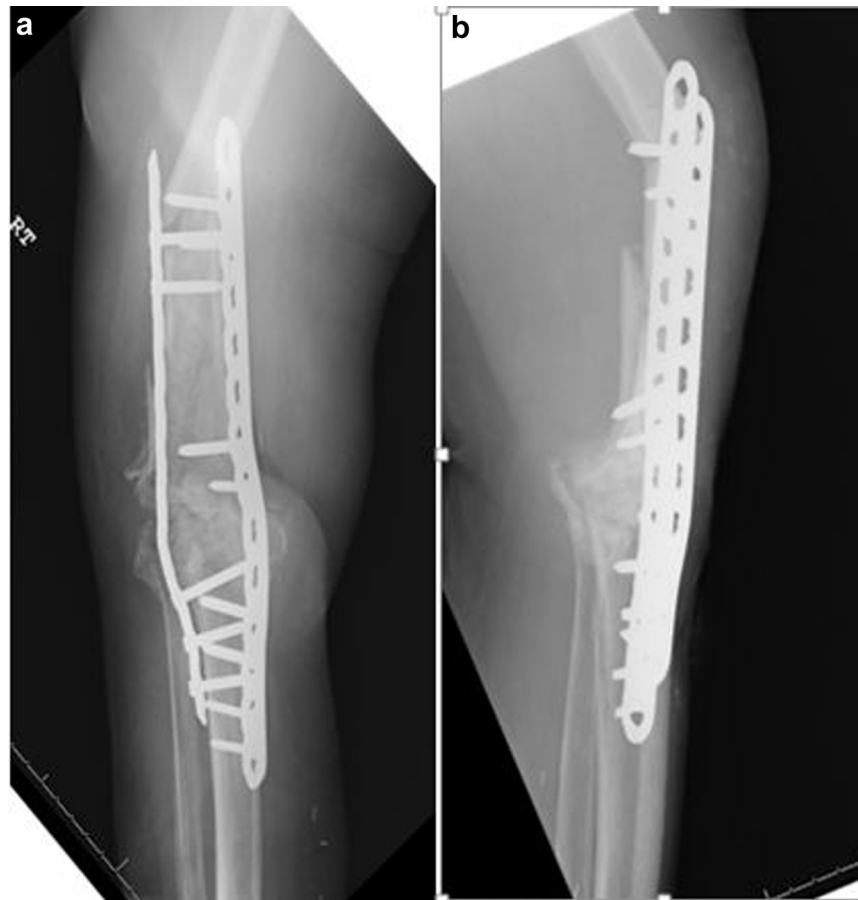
Injury radiographs. Anteroposterior (a) and lateral (b) radiographs showing peri-implant femur fracture.
